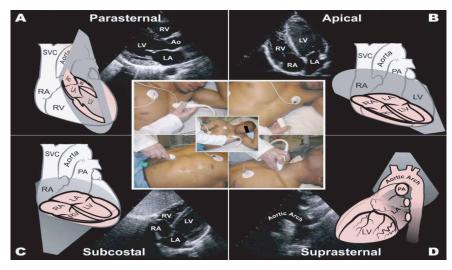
showing transducer placement for each of the major echocardiographic views: (A) parasternal location for parasternal long and short-axis; (B) apical location for apical four-, two-chamber and long-axis views; (C) subcostal location for subcostal views; (D) suprasternal location for suprasternal location for suprasternal location
